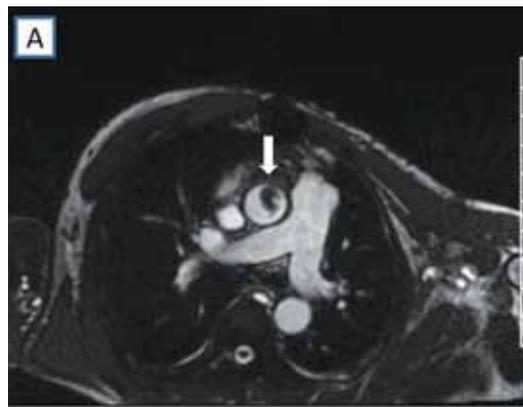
Cardiac MR imaging study shows irregular mobile mass that has a pedunculated attachment to the anterior wall of the ascending aorta, just above the aortic root. Arrows indicate mobile mass. A: transverse view of the ascending aorta; B: sagittal section view.
